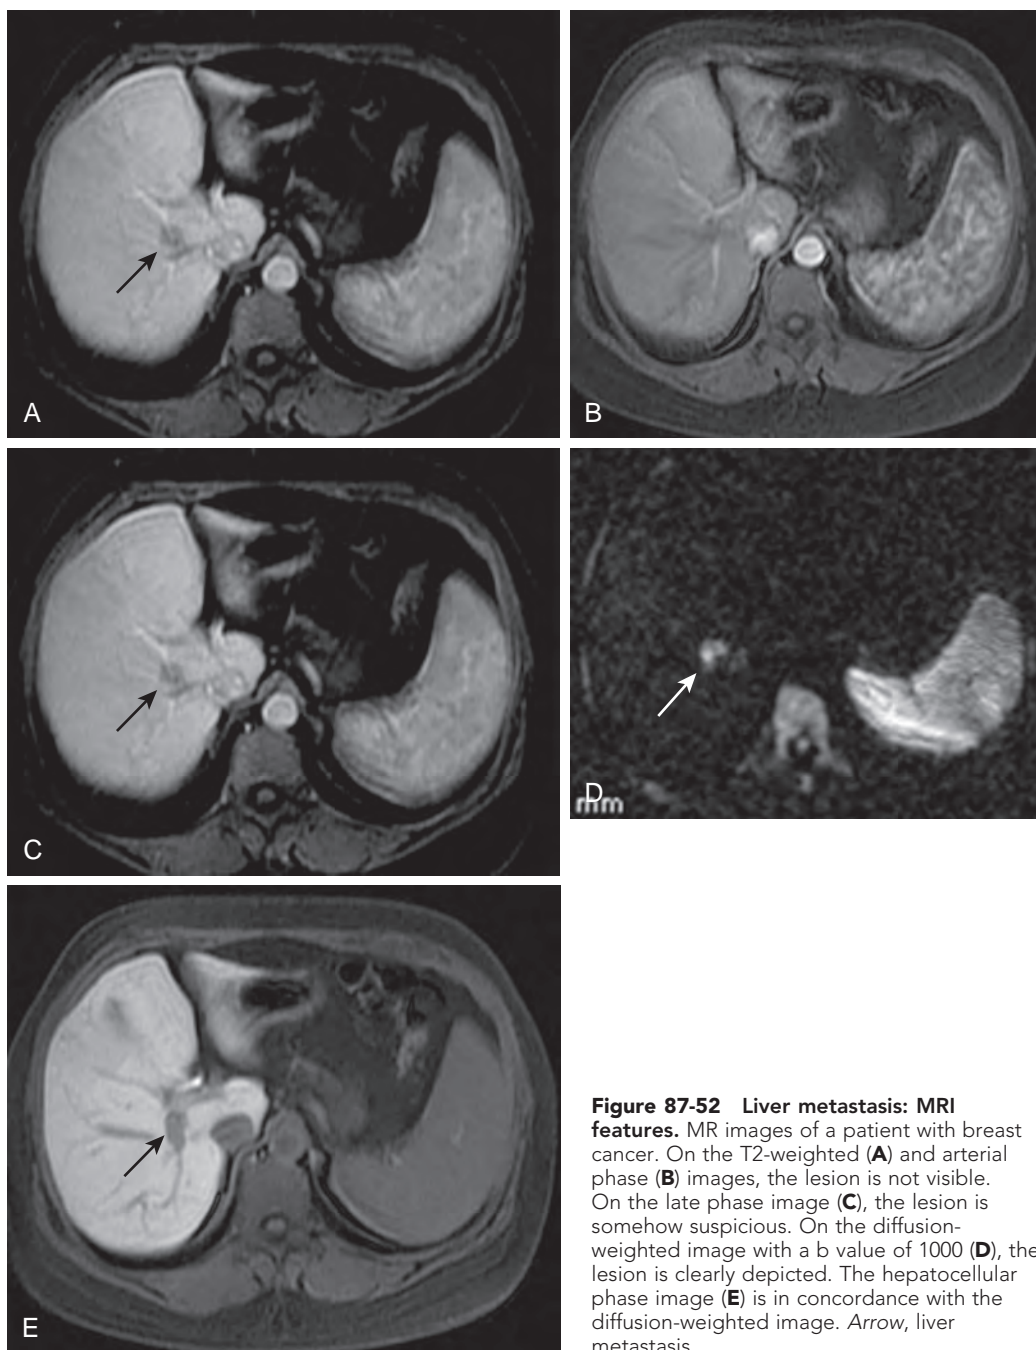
Liver metastasis: MRI features. MR images of a patient with breast cancer. On the T2-weighted (A) and arterial phase (B) images, the lesion is not visible. On the late phase image (C), the lesion is somehow suspicious. On the diffusion-weighted image with a b value of 1000 (D), the lesion is clearly depicted. The hepatocellular phase image (E) is in concordance with the diffusion-weighted image. Arrow, liver metastasis.
